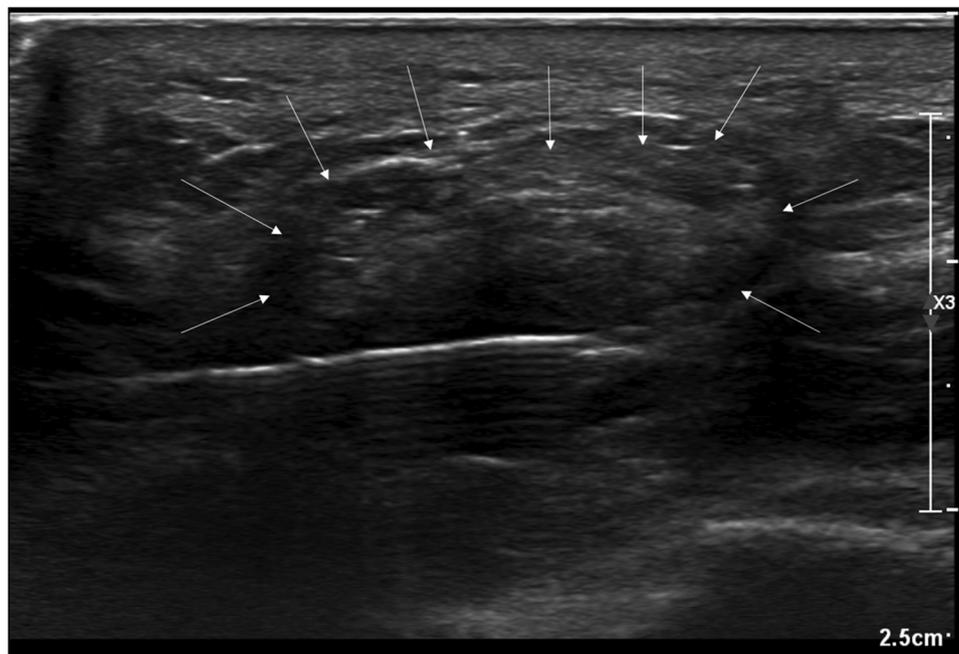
32-year old male soccer player with plantar fasciitis. Transverse sonogram showing 23 gauge needle placed on deep surface of plantar fascia (outlined by arrows) immediately prior to corticosteroid-local anaesthetic injection.
